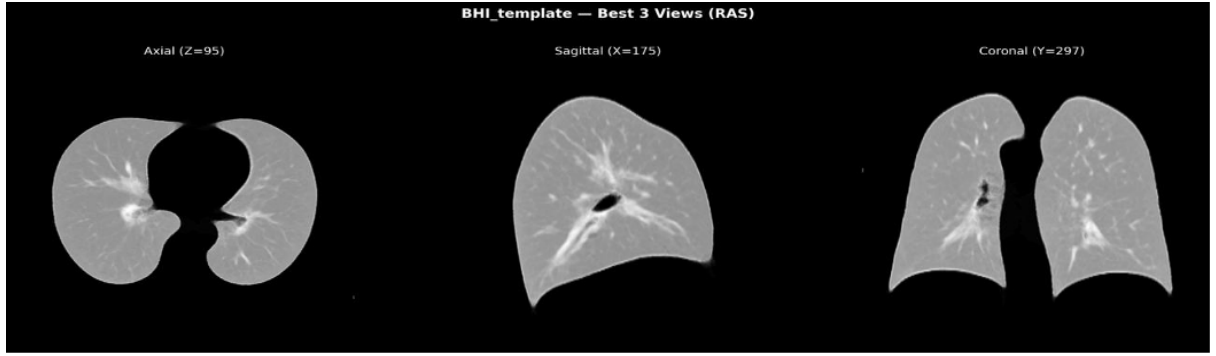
Axial, sagittal, and coronal views of the template CT
